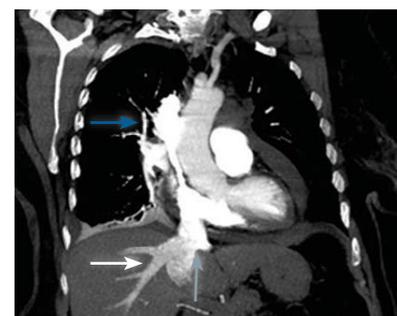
A maximum intensity projection reconstructed image from contrast-enhanced computed tomography shows a pericardial effusion, as well as signs of right ventricular strain, contrast pooling within the superior vena cava (blue arrow), and reflux of contrast into inferior vena cava (gray arrow) and hepatic veins (white arrow)
